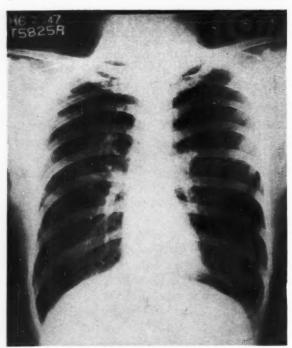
Case r. X-ray of the chest.
